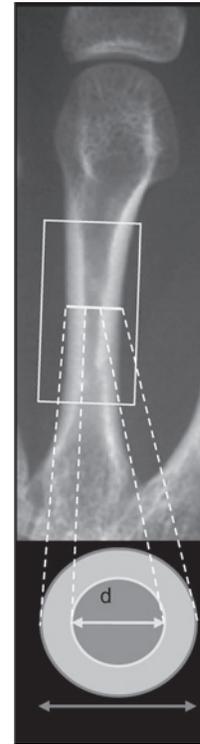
Radiogrammetry of the second metacarpal; originally, only the midshaft, as indicated by the horizontal line, was used for measurements. Newer direct digital x-ray methods use a larger ROI covering a large part of the diaphysis, as indicated by the box.
